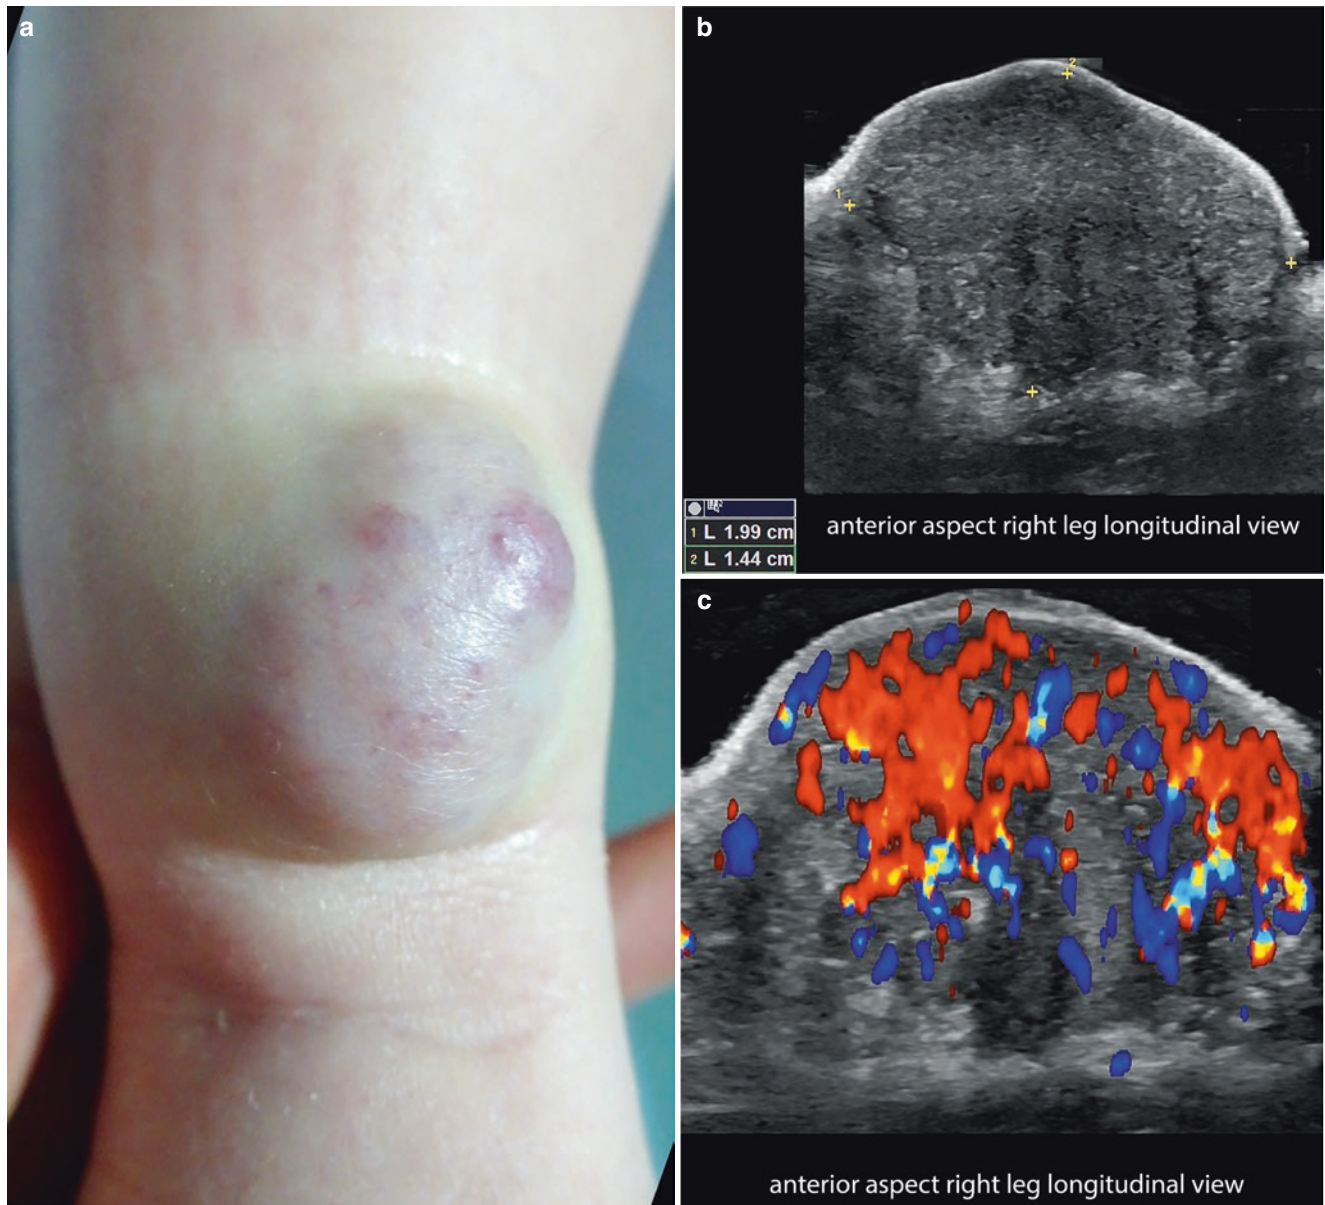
Rapidly involuting congenital hemangioma (RICH). 3-month follow-up of the same case as in Fig. 4.8, which has been under observation and without medication. (a) Clinical image (anterior aspect of the distal part of the right leg). (b and c) Greyscale and color Doppler ultrasound (longitudinal views) demonstrates 2.0-cm (long) \times 1.4-cm
